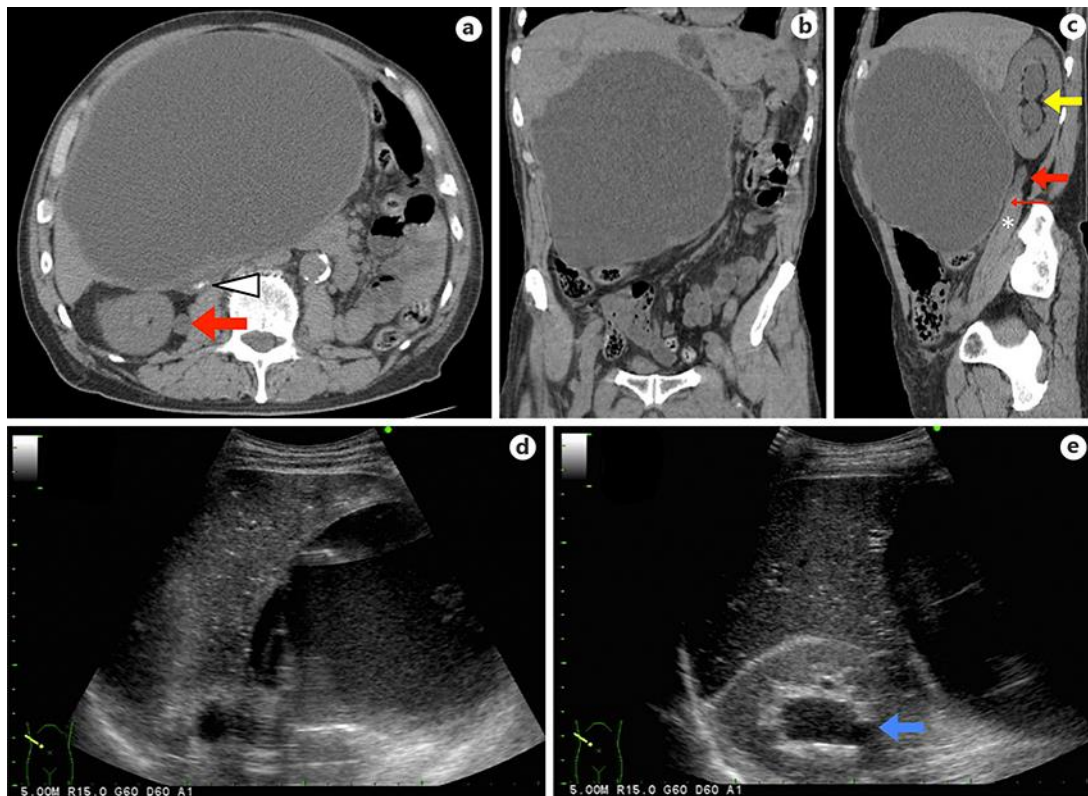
Plain CT transverse (a), coronal (b), and sagittal (c) sections showing a 20-cm cystic lesion in the right lobe of the liver and dilatation of the right pelvis (yellow arrow) and proximal ureter (red arrow) due to compression of the ureter (thin red arrow) wedged between the hepatic cyst and iliopsoas muscle (asterisk). Gallstones were indicated in the compressed gallbladder (arrowhead). Abdominal US showed a large cystic lesion with homogeneous contents without a septum or calcifications (d), and the right kidney with hydronephrosis (blue arrow) (e).
